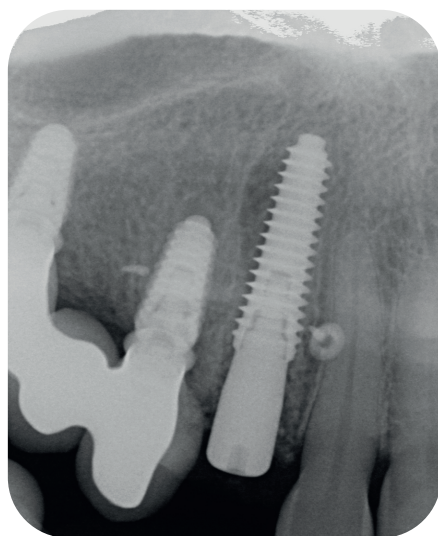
Immediate postop radiograph following implant placement and graft
